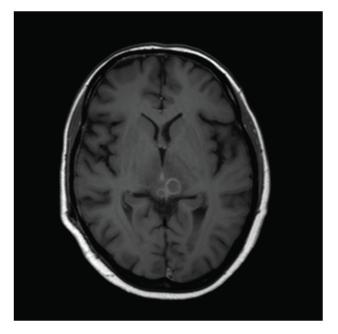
MRI T1 weighted axial section post contrast showing well defined contrast enhancing lesions in the region of mid brain
